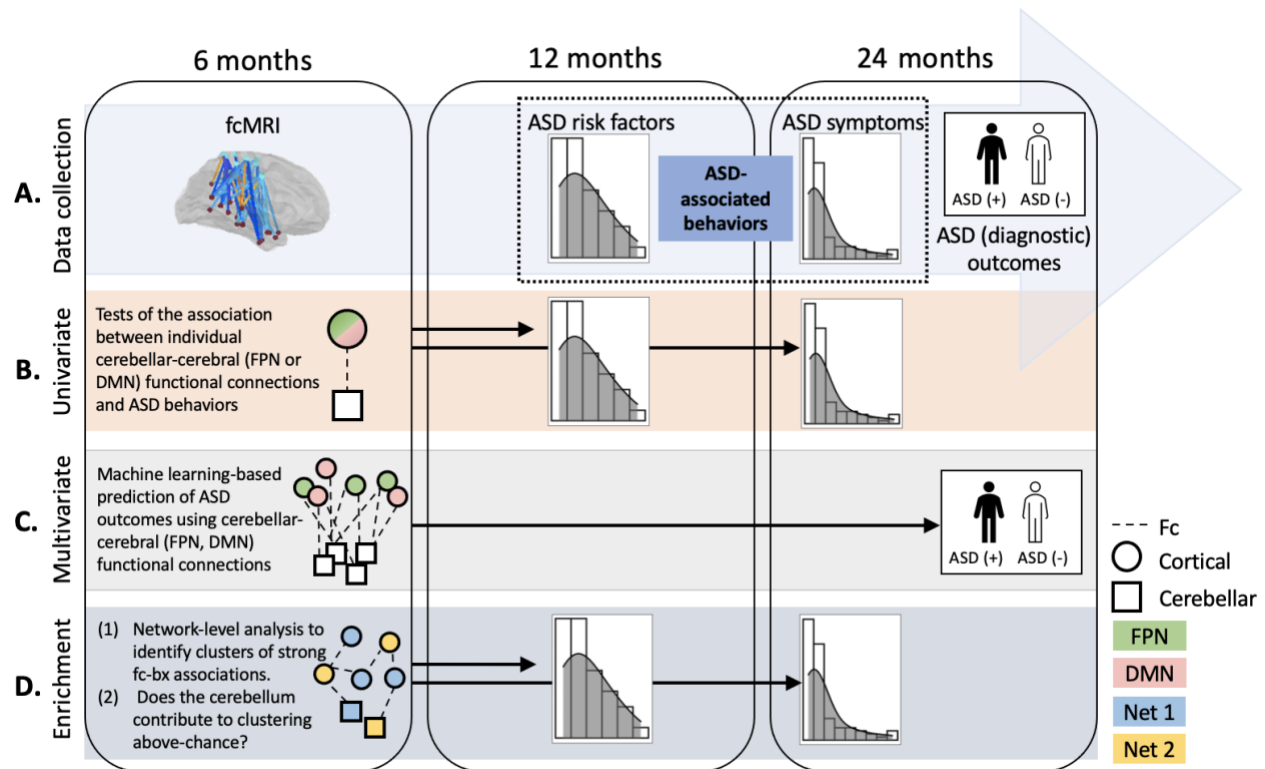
Study design. Summary of the (A) data collection timeline and (B-D) three-part analytic plan. Functional connectivity magnetic resonance imaging (fcMRI) data were collected at 6 months, continuous measures of ASD behavior were collected at 12 and 24 months, and ASD diagnostic outcomes were evaluated at 24 months. Circles and squares represent regions of interest (ROIs) located in the cortex and cerebellum, respectively. Colors (green, pink, blue, yellow) denote ROI network assignments (Nets 1 and 2 being arbitrary non-FPN, non-DMN networks).
